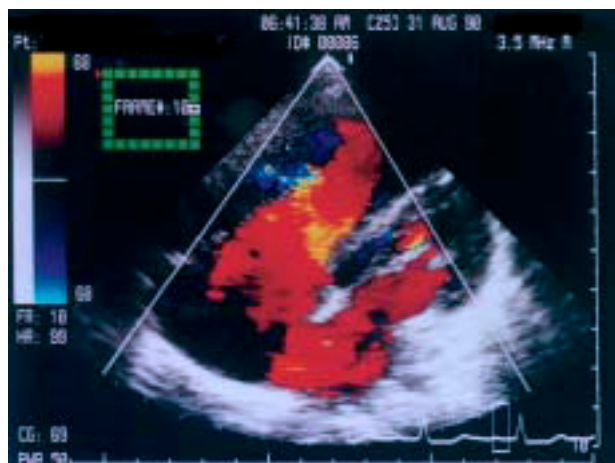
Four-chamber view showing a large secundum type defect in the atrial septum. Blood flow crossing the atrial septal defect is apparent on Doppler echocardiography.
